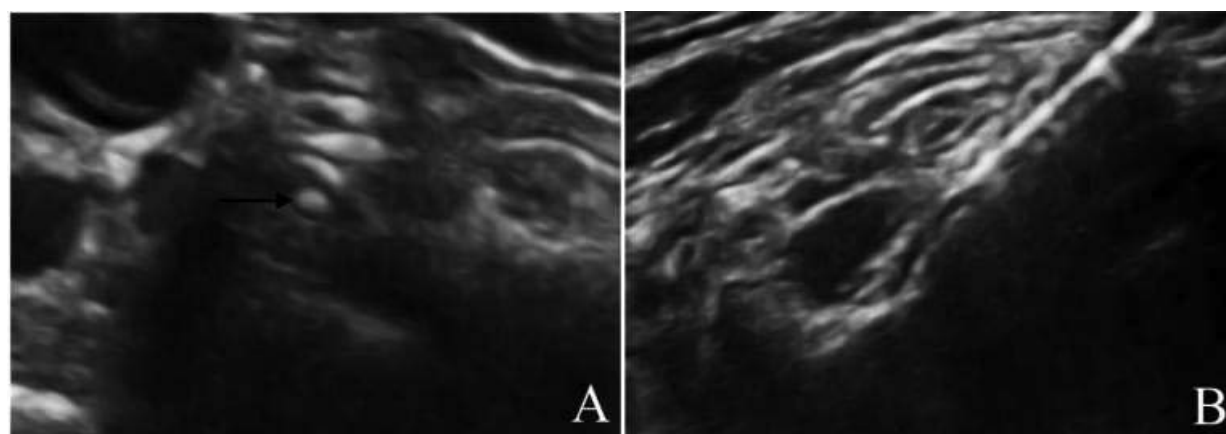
Ultrasonographic examination. A) ultrasound showed the nerve root area; B) puncture needle reached the nerve root area).
